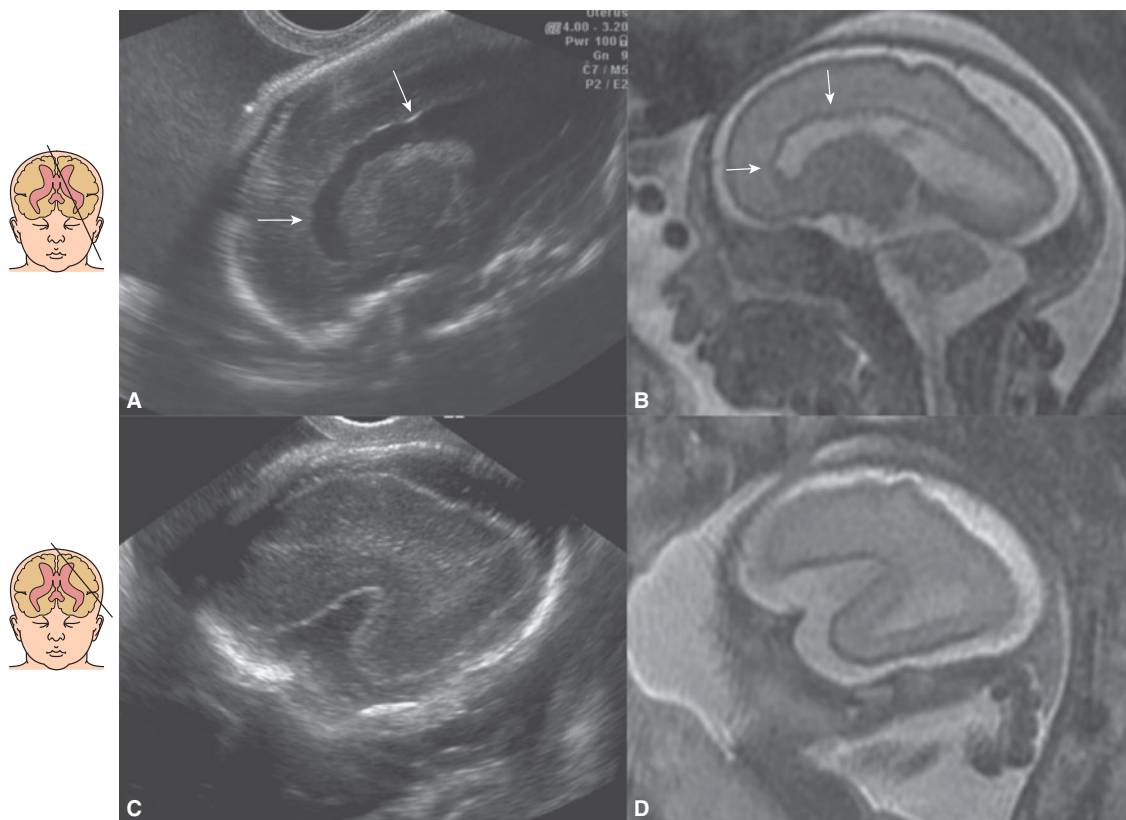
Sagittal transvaginal US and magnetic resonance imaging (MRI) at 29 postmenstrual weeks in a fetus with CMV. The MRI examination was performed 3 days after the US. Parasagittal US (A) and MRI (B) show mild ventriculomegaly with irregular, dentate ventricular walls (arrows) due to ventriculitis and ependymal damage. More lateral US (C) and MRI (D) views show a wide sylvian fissure and almost complete lack of sulcation.
